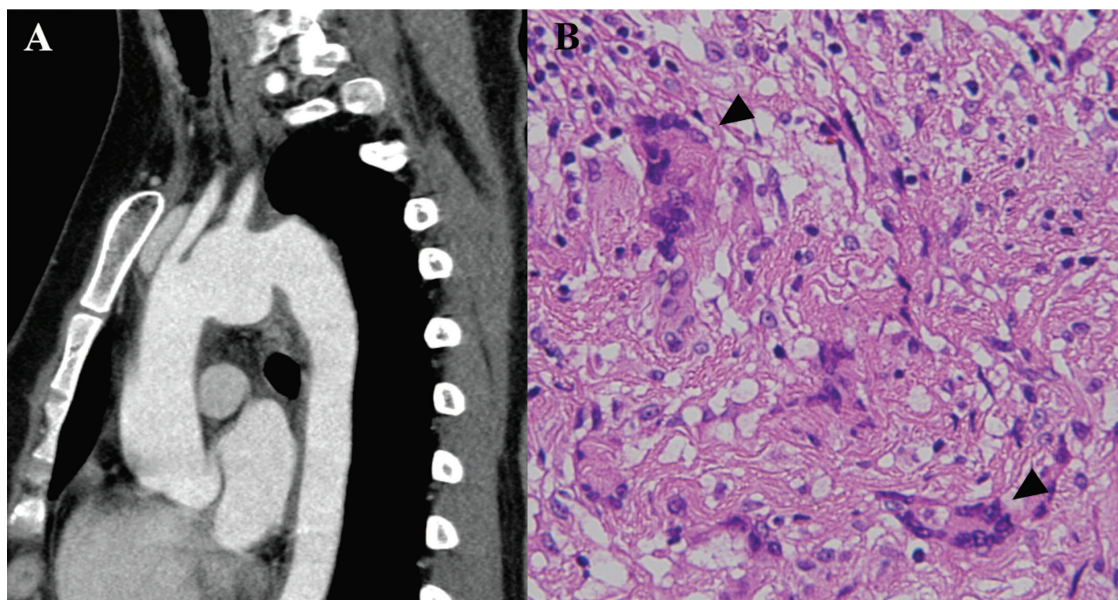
A. Computed tomography scan shows thoracic aortic aneurysm. B. Pathological findings of aortic aneurysm (arrowheads) reveal granulomatous inflammation with giant cells.
